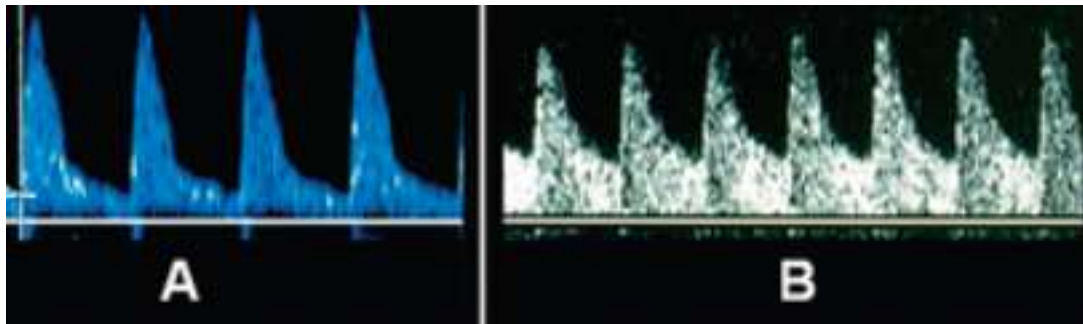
Normal and abnormal MCA waveform images(A) Normal MCA Doppler waveforms (B) Abnormal MCA Doppler waveforms with increased end-diastolic velocity indicating possible hypoxia
